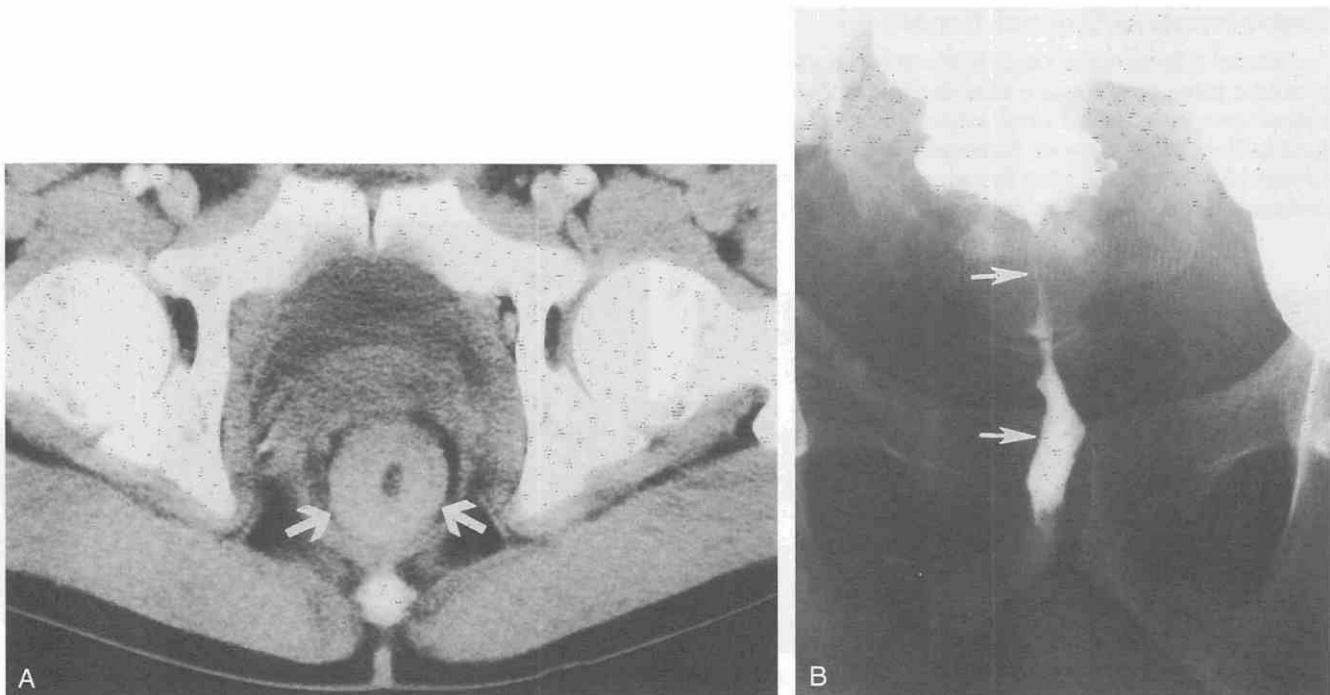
Primary "signet ring" cell carcinoma of the rectum. A, CT scan shows concentric bowel wall thickening (arrows) with the "target sign" in the rectum. B, Double-contrast barium enema shows a long segment of concentric luminal narrowing (arrows) along the rectum with minimal irregularity of the mucosal surface.
